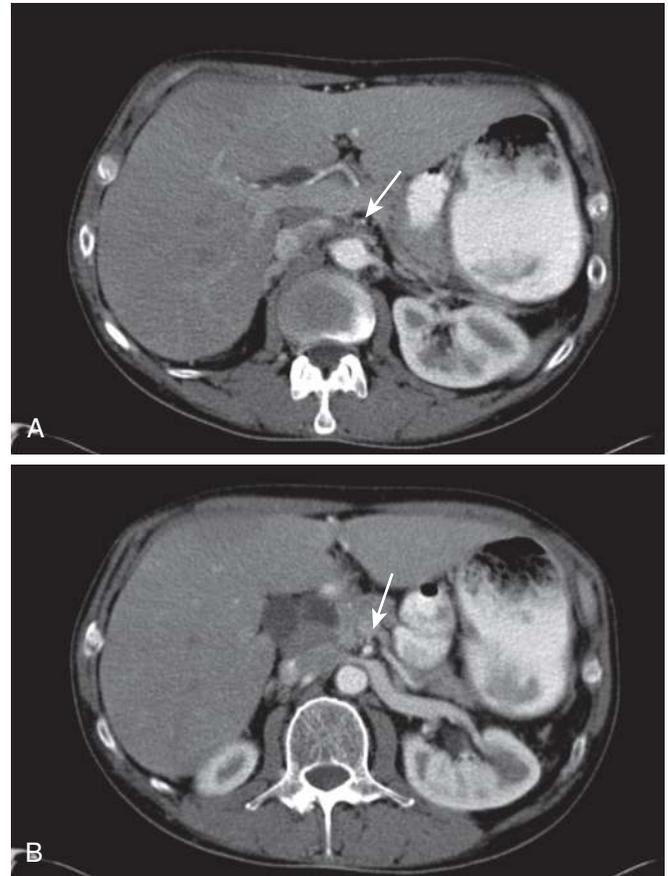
CT arteriograms in a patient with an occluded celiac axis and superior mesenteric artery (SMA). A, The origin of the SMA is shown with the arrow. There is no contrast within the lumen of the vessel at this cross section. B, The SMA is shown with the arrow in this cross section that is 10 mm caudal to the first image. The artery is patent at this level, as reflected by the contrast within the lumen.
